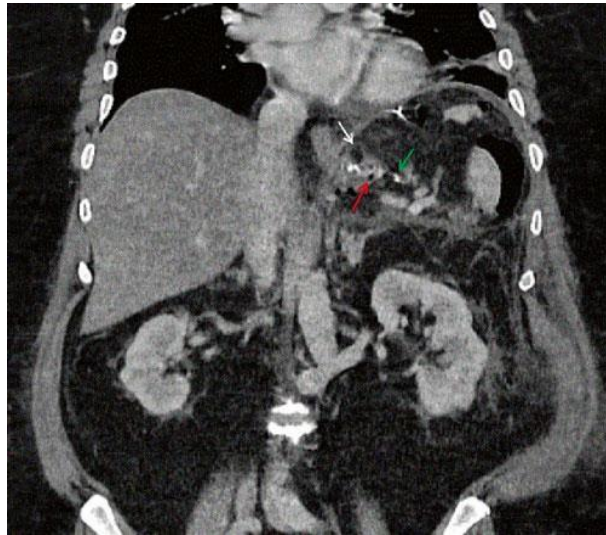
Intense contrast-enhanced CT scan reveals acute leaking after laparoscopic stoma repair. You can see the lumen of the sleeve (shown by the white arrow), the trace of contrast material that can be seen outside the lumen (shown by the green arrow), as well as the air foci that can be seen close to the construction of the sleeve (indicated by the red arrow) (23).
